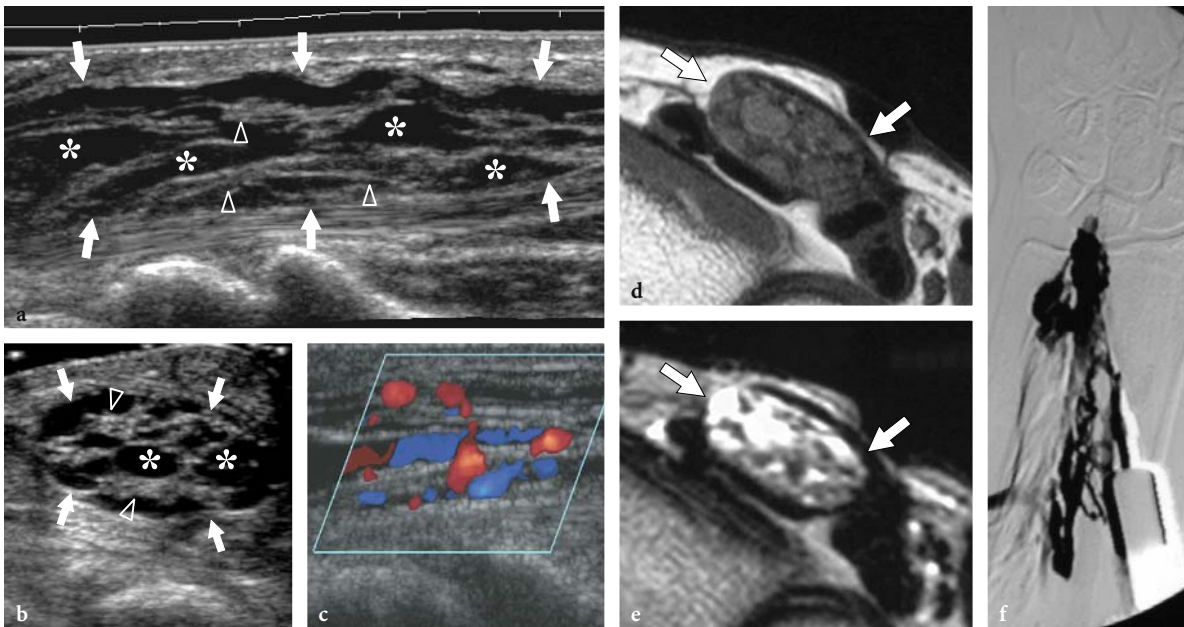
Hemangioma of the median nerve in a 40-year-old woman with carpal tunnel syndrome and a large intramuscular hemangioma extending through the flexor muscles of the forearm down to the carpal tunnel. The patient underwent release of the retinaculum and partial resection of the mass with removal of the flexor digitorum superficialis muscle. a Long-axis and b short-axis 17–5 MHz US images obtained at the distal radius show an enlarged median nerve (*arrows*) with intraneural abnormal fluid-filled spaces (*asterisks*) running alongside the fascicles (*arrowheads*). c Longitudinal color Doppler 12–5 MHz US image reveals slow-flowing blood within the intraneural spaces indicating a hemangioma. Vessels are compressible and exhibits venous waveforms. d,e Correlative transverse d T1-weighted and e T2-weighted MR images show increased T2 signal intensity in the epineurium surrounding the fascicles of the median nerve (*arrows*), due to the presence of abnormal vessels within the nerve substance. f Digital subtraction angiography confirms the presence of a venous network in the median nerve
